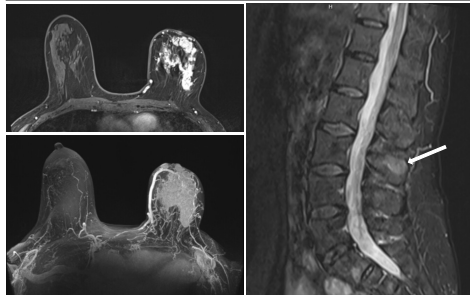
Breast and Lumbar MRI
